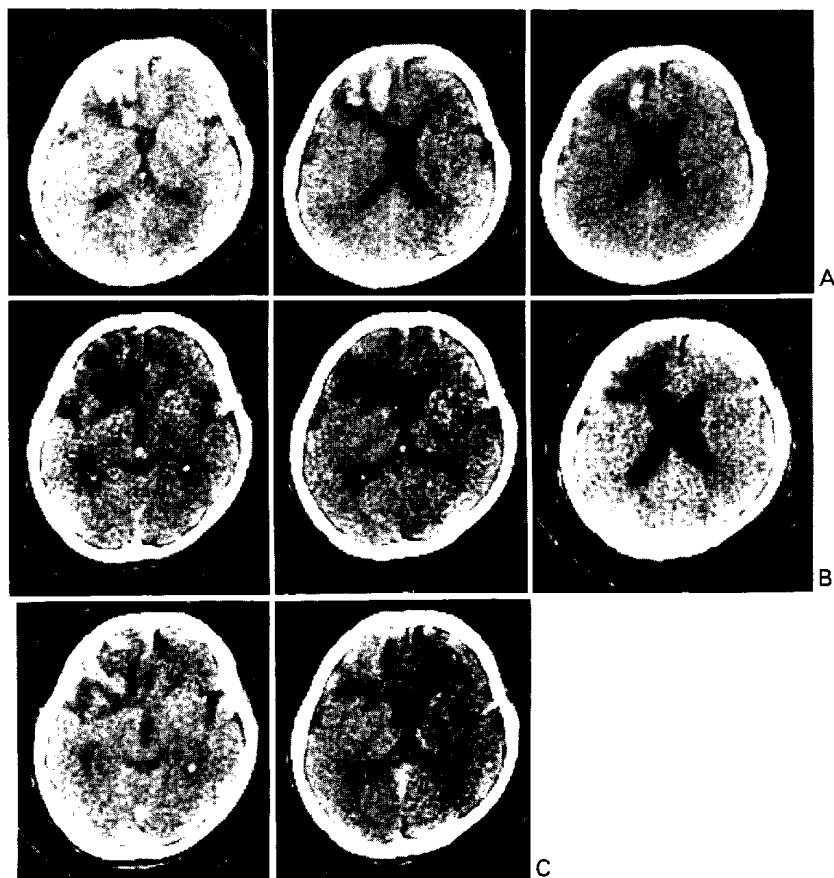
Intracerebral hematoma, 50-year-old male. Multiple hematomas in the left frontal lobe are identified by CT, taken 4 days after trauma (A). CT, taken 18 days after trauma, shows that the hematoma visible as low density area (B). Density of the low density area was raised remarkably by intravenous contrast material injection (C).
